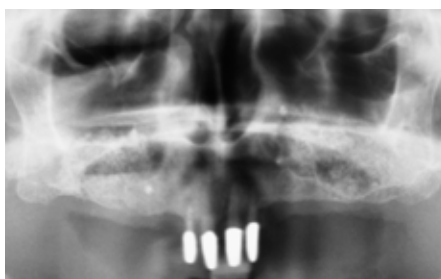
Postoperative panoramic radiograph shows filling of both maxillary sinus cavities.
